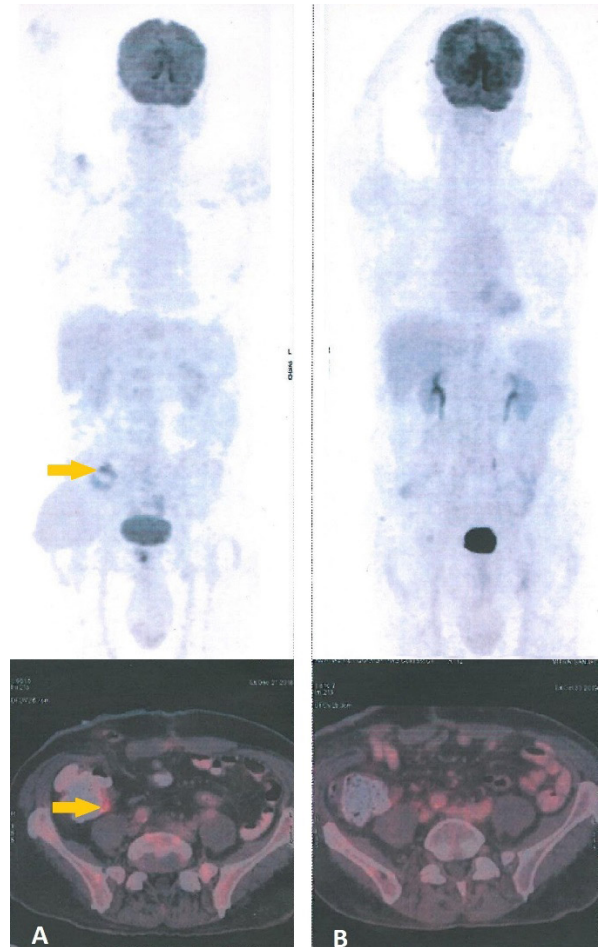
Comparative images of PET CT scan of the patient showing abnormal metabolic activity (FDG avid focus corresponding to appendicular stump - marked by yellow arrow) on post-operative day 30 (A) which resolved after six cycles of chemotherapy and radiotherapy (B)
